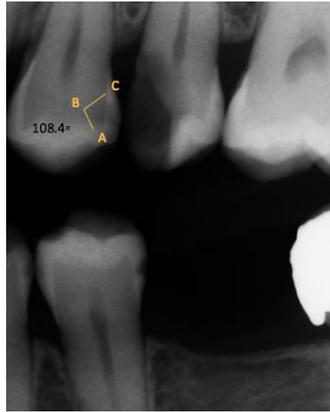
Bitewing radiograph image shows the radiographic measurement of PLAD; A) The most coronal radiolucent point. B) The deepest axial radiolucent point. C) The most apical radiolucent
